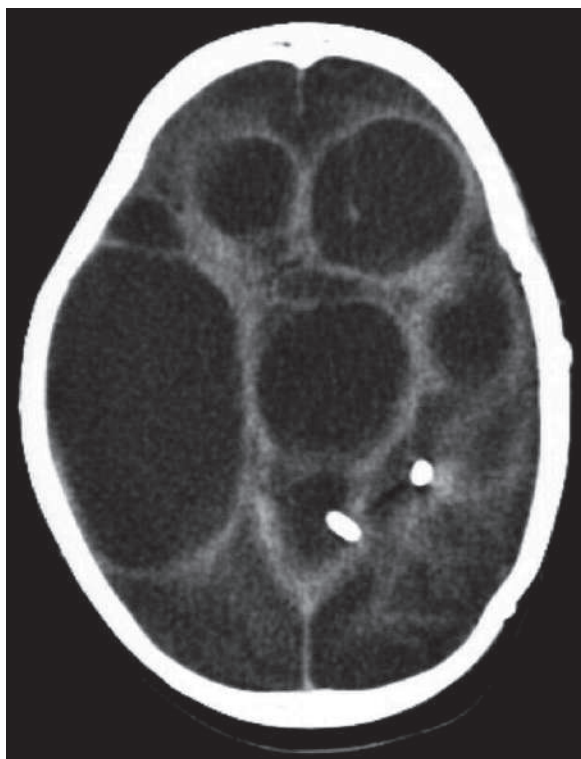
Axial nonenhanced brain CT of a neonate shows multiloculated hydrocephalus
